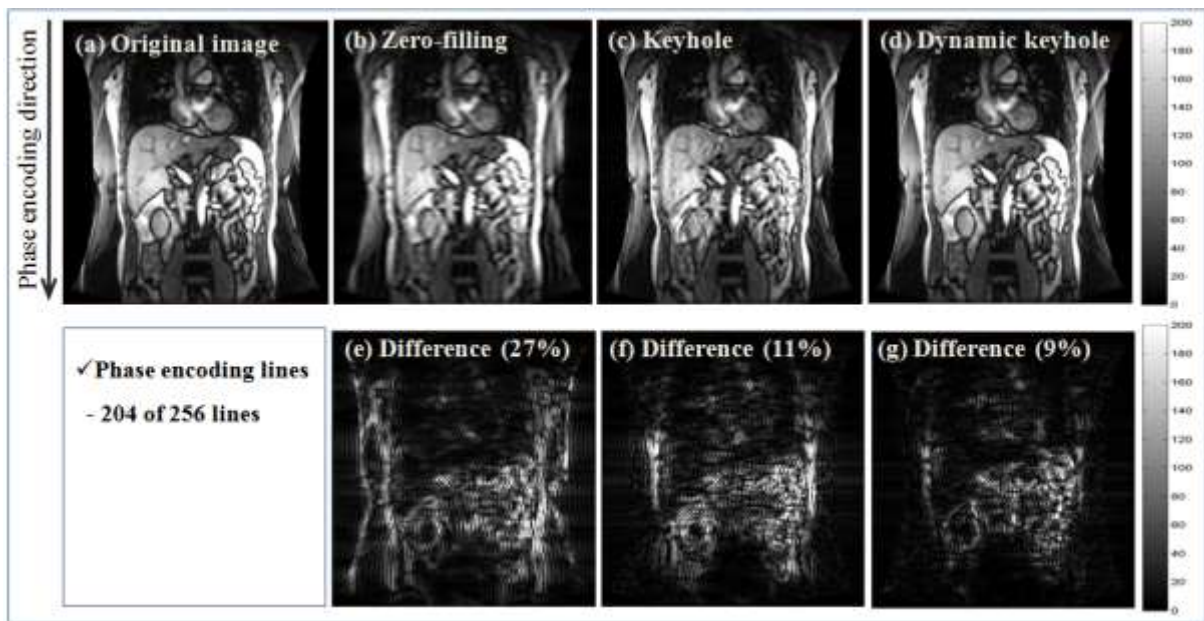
Reconstructed MR images utilizing (b) zero-filling, (c) conventional keyhole and (d) dynamic keyhole, where 204 of 256 lines were reused. (e), (f) and (g) display the difference between the original image (a) and the reconstructed images for the zero-filling (27%), conventional keyhole (11%), and dynamic keyhole (9%) methods, respectively.
